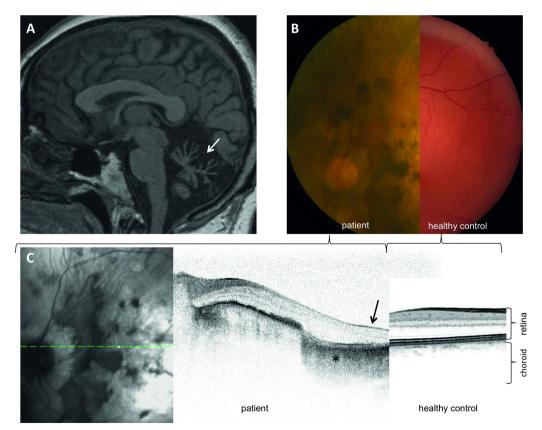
MRI, funduscopy and optical coherence tomography (OCT). MRI shows marked cerebellar atrophy (arrow, A). Fundus photography reveals retinal degeneration with pigment clumps (B left). OCT (green line indicates site of infrared fundus photography, C left) verifies retinal thinning (arrow) and atrophy of choroidal vessels (asterisk) in the patient (C middle) compared to control (C right). OCT was acquired with the following settings: automatic real time (ART) 1 and high speed (HS). Because of severe nystagmus and inability to fixate due to the loss of vision, an OCT scan of higher quality than 22 dB was not possible in this patient.
